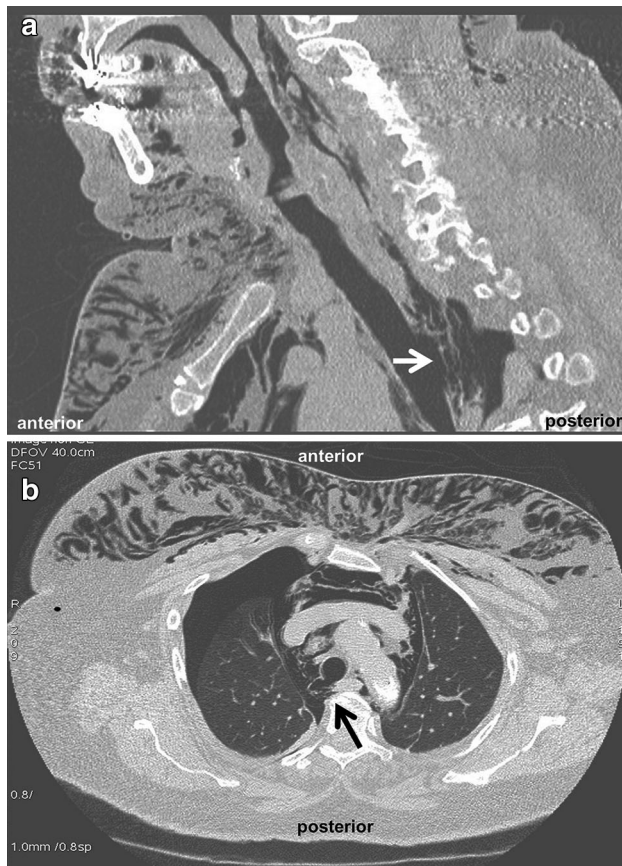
Chest computerized tomography (CT) scans (a) sagittal view: rupture of the posterior tracheal wall (white arrow), 2.5 cm in length at 24 cm from the teeth; (b) axial view: rupture of the right posterolateral tracheal wall (black arrow)
